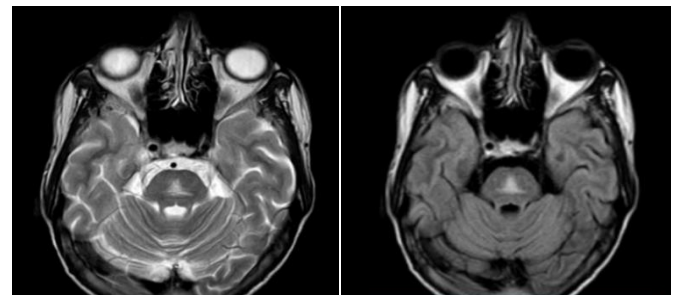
Axial T2/FLAIR images show classical trident shaped high signal intensity in bilateral median hemispheres, seen in Osmotic demyelination syndrome
